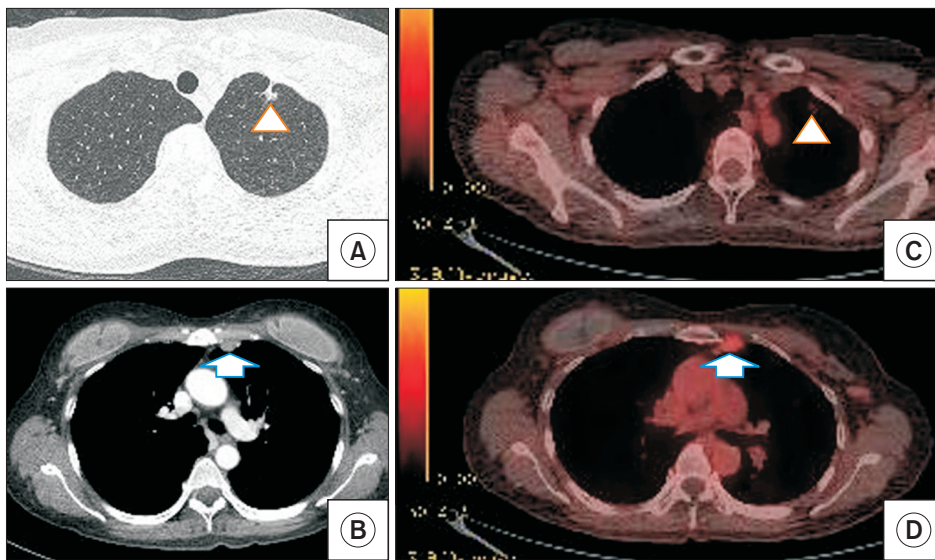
Chest computed tomography shows an approximately 12-mm subpleural part-solid nodule (arrowhead) in the apicoposterior segment of the left upper lobe (LUL) (A) and a 13-mm nodular lesion (arrow) in the left internal mammary chain (B). Positron emission tomography shows ill-defined hypermetabolism (maximum standardized uptake value [SUV], 1.2; arrowhead) at the apicoposterior segment of the LUL (C) and focal hypermetabolism (maximum SUV, 3.1; arrow) in the left internal mammary area (D).
